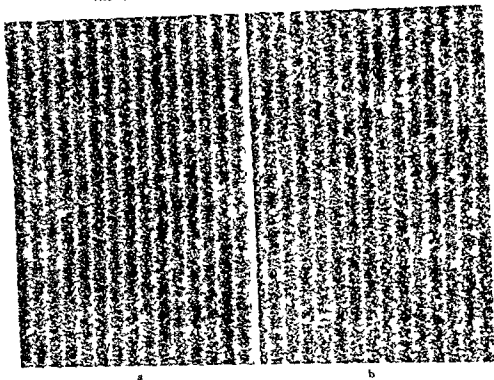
Roentgenograms of a grid obtained with par speed screens. The sharper appearance of the juncture between the ridges and valleys of the grid lines characterizes the improvement gained with the vacuum cassette (a) over a spring-closed cassette with new intensifying screens (b).
